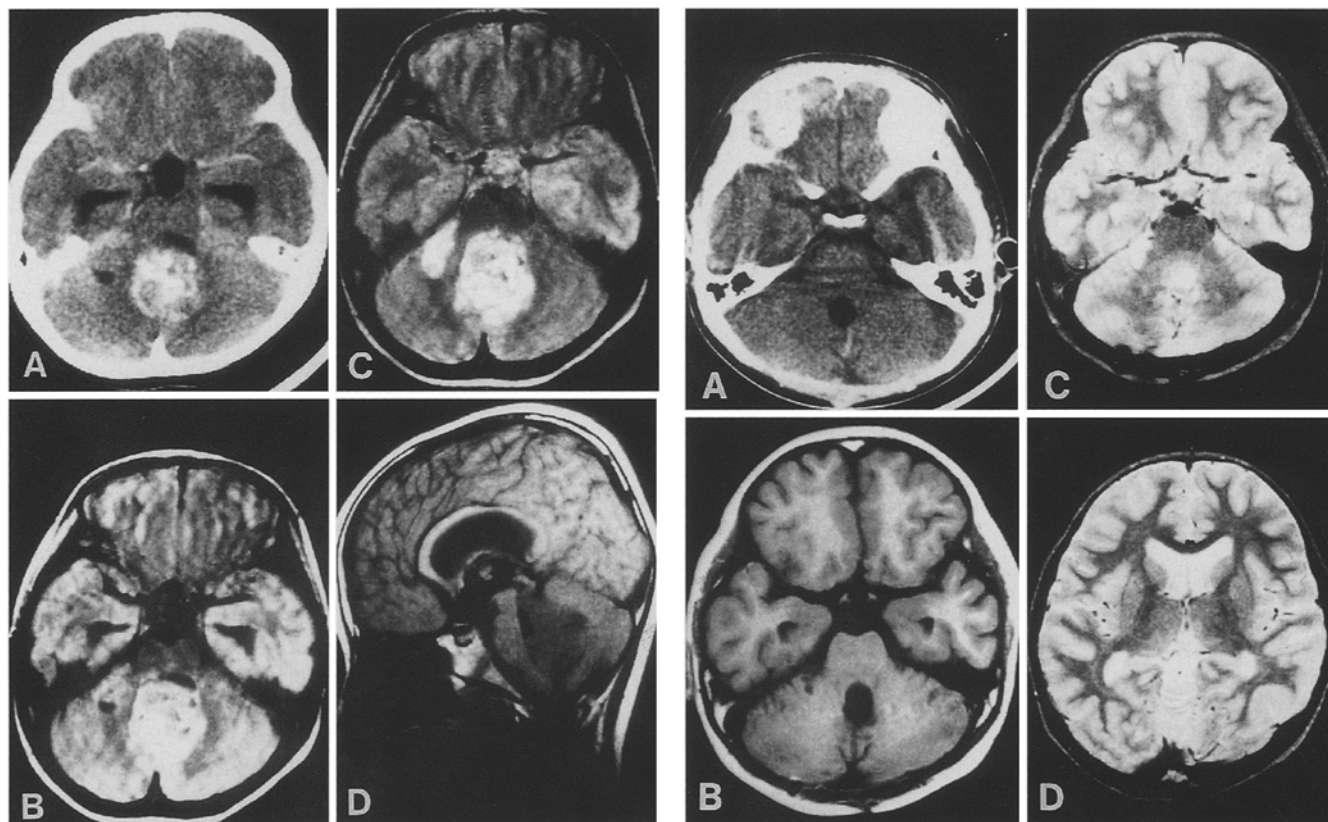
A Computed tomographic (CT) scan with contrast enhancement demonstrating a large midline cerebellar tumor. B Magnetic resonance imaging (MRI): the same findings on enhanced T₁-weighted imaging. C The proton image showed the tumor with a lateral recess extension. D On the sagittal section, the large tumor almost obstructs the aqueduct
